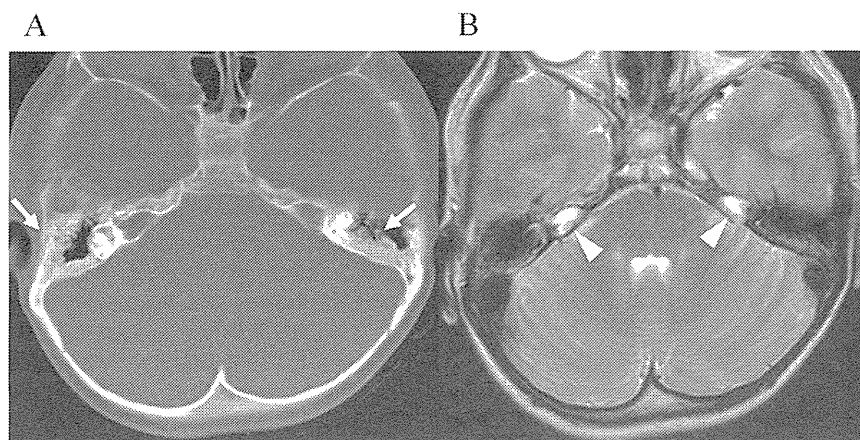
Radiological examination of the patient 2 years after initiation of interferon therapy and prior to sirolimus treatment. (A) Axial noncontrast CT revealed an obvious increase in bone density of the mastoid air cells (arrow). (B) Axial noncontrast T2-weighted MRI revealed improvement of cerebellar hernia (arrowhead).
